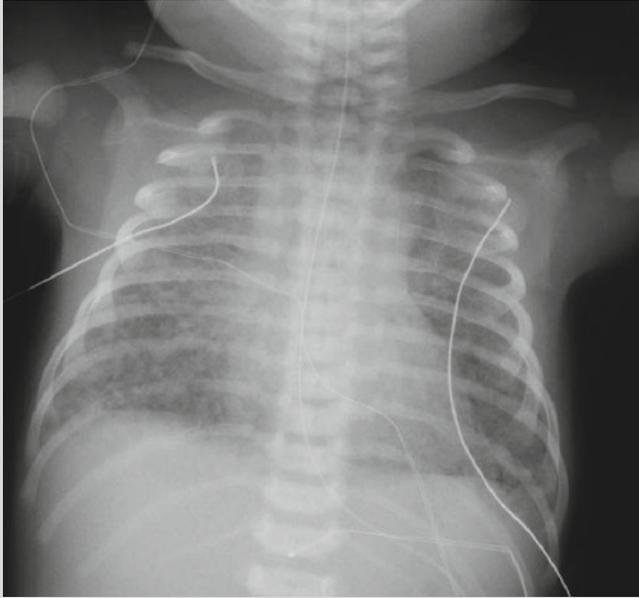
Chest radiograph on admission showing mild hyperinflation and patchy infiltrates
